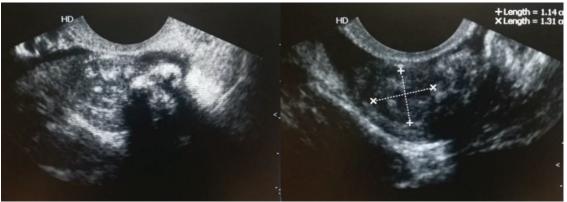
ovarian fibromata on Grey scale Ultrasound
